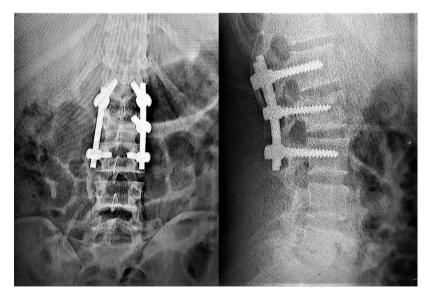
Anteroposterior and lateral radiographs of a patient with L2 vertebra fracture who received SSF with the inclusion of the fractured vertebra.
